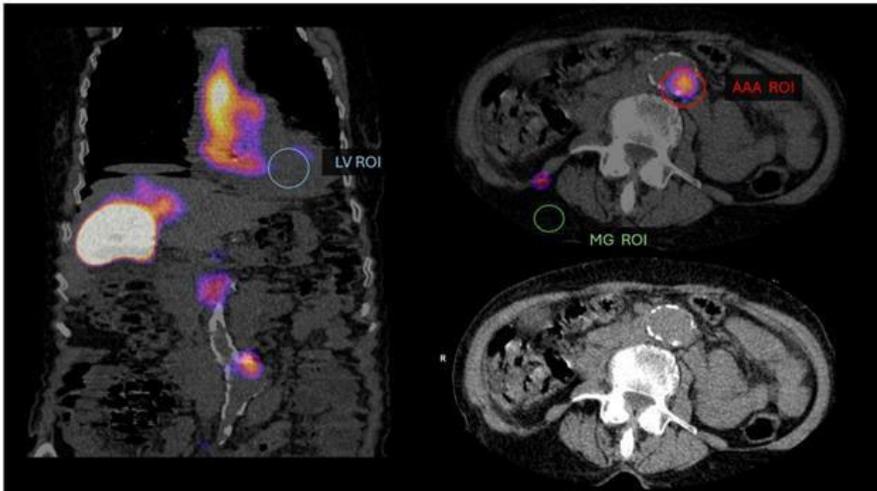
Regions of interest (ROIs) delineated on SPECT/CT images. ROIs were drawn on the aneurysmal wall (red), left ventricular blood pool (LV, blue), and gluteal muscle (GM, green) to calculate target-to-background ratios (TBR).
